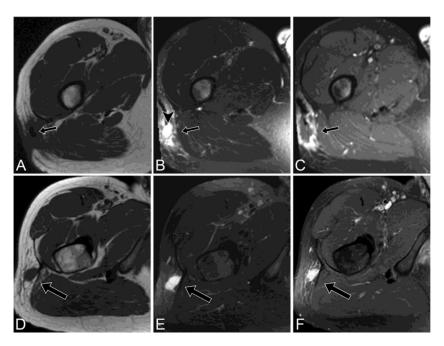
Recurrent subcutaneous undifferentiated pleomorphic sarcoma in the upper right lateral thigh in a 42-year-old man. The tumor was surgically resected in October 2015. Postoperative axial T1-WI (A) shows hypointense scar at the resection site (arrow). Axial FS T2-WI (B) shows heterogeneous hyperintense granulation tissue in surgical bed (arrow), surrounding the homogeneously high signal of the postoperative fluid collection (arrowhead). Axial postcontrast FS T1-WI (C) shows peripheral enhancement around the small postoperative fluid collection (arrow). Follow-up MRI of the right thigh in May 2016 now shows a small soft tissue nodule in the surgical bed. The nodule is isointense on axial T1-WI (D), hyperintense on axial FS T2-WI (E) and shows homogenous enhancement on axial postcontrast FS T1-WI (F, large arrows), consistent with tumor recurrence.
